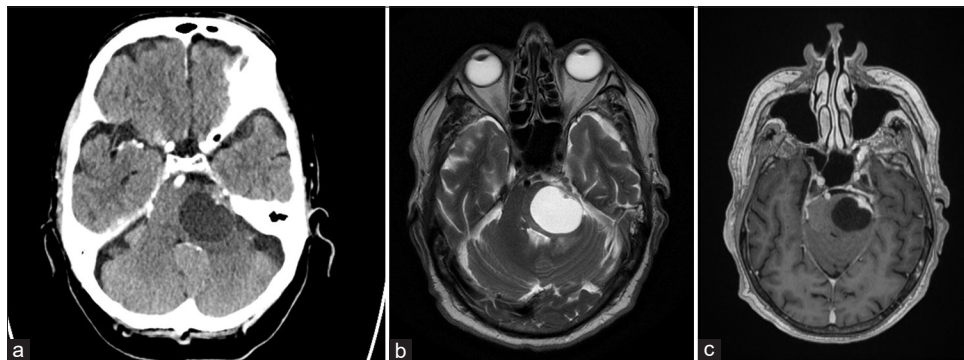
Preoperative radiological images. CT-scan of the brain without contrast showed a sharply delineated cystic lesion located in the left dorsolateral pons (a). There appear some calcifications located in the anterolateral solid mass of the lesions. Contrast-enhanced T2-weighted MRI images again showing the hyperintense aspect of the cystic fluid (b). Limited edema can be noted at the dorsal side of the tumor. On the contrast-enhanced T1-weighted images, the tumor mass and part of the cyst wall enhanced homogeneously (c).
